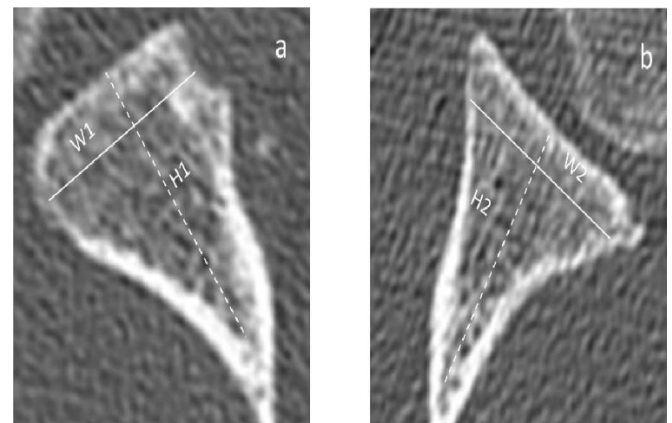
Computed tomography of affected (a) and non-affected (b) shoulders of a middle-aged patient. W1: Width of affected glenoid; H1: Axis of affected glenoid; W2: Width of unaffected glenoid; H2: Axis of unaffected glenoid.
